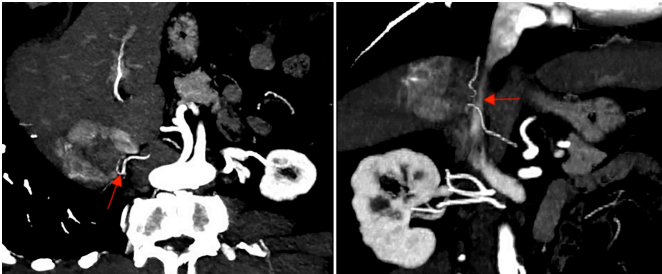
CT angiography MIP images show the right inferior phrenic artery (RIPA, yellow arrow) originating from the aorta.
